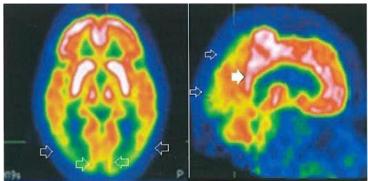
¹⁸FDG PET of the brain of a person with DLB. Transparent arrows mark hypometabolic occipital (optical cortex) and parietal areas, and filled arrow marks preserved metabolism in the posterior cingulate cortex. From the book Nuclear Medicine, Faculty of Medicine, Belgrade 2020.
